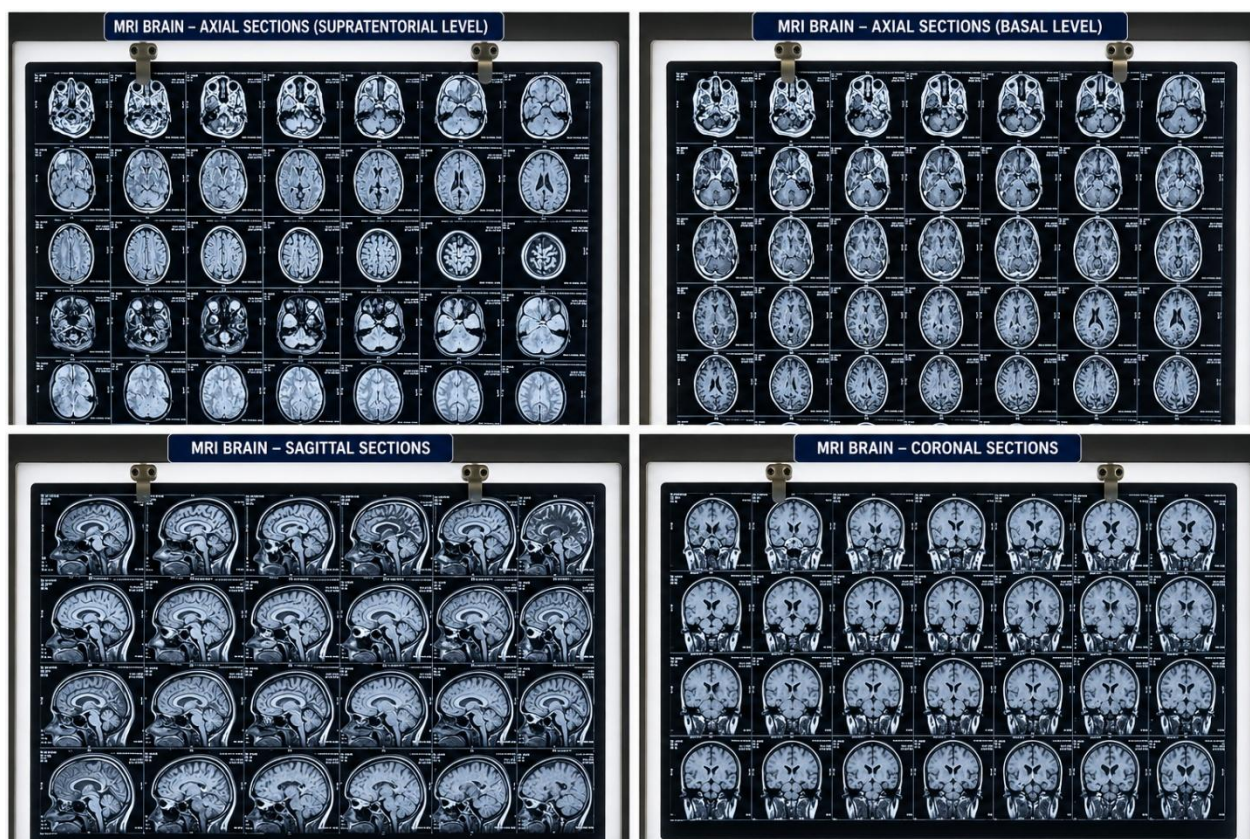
Serial MRI Brain Images Demonstrating Paradoxical Progression of Intracranial Tuberculomas During Anti-Tubercular Therapy
